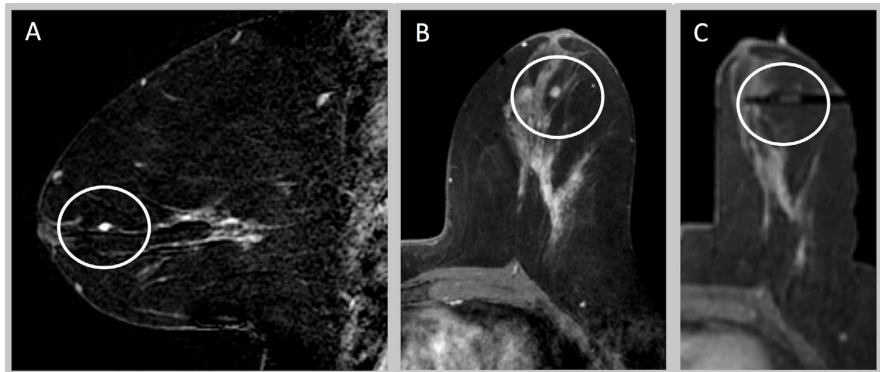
Case 4: A. Sagittal T1 CE FS subtraction MRI demonstrated an oval mass in the left breast subareolar anterior depth (circle) also circled on non-subtraction FS T1 CE axial MRI (B). MRI-guided biopsy axial T1 CE image (C) demonstrates the biopsy needle in appropriate location (circle).
